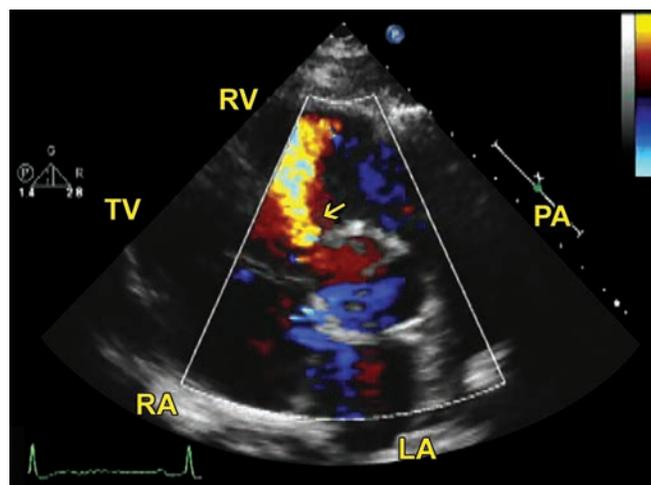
Short axis view with color Doppler showing VSD (arrow).
